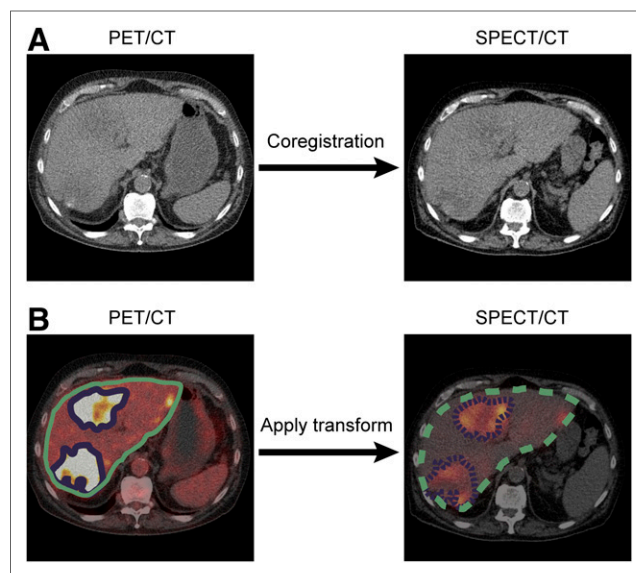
Example of tumor delineation and absorbed-dose estimation. (A) Using liver contour, low-dose CT of PET/CT was matched to low-dose CT of SPECT/CT. Tumors were automatically defined using threshold. (B) Liver and tumor contours were transferred from PET/CT to SPECT/CT, and absorbed doses were calculated.
